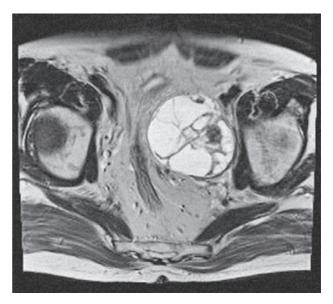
MRI (T2-weighted image) Multilocular cystic mass with uniform smooth wall on the left side of pelvis under the left common iliac artery.
